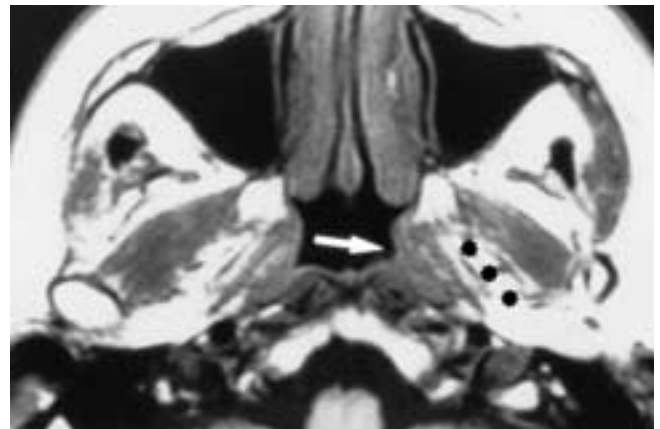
T1-weighted nasopharyngeal carcinoma. Axial noncontrast T1-weighted image shows an early tumor in the left fossa of Rosenmüller (*arrow*). Note the normal appearance of the parapharyngeal space (*), thereby staging this tumor as T1. (From Chong VFH, Fan YF, Mukherji SK. Carcinoma of the nasopharynx. *Semin Comput Tomogr Ultrasound MRI* 1998;19:449–462.)
